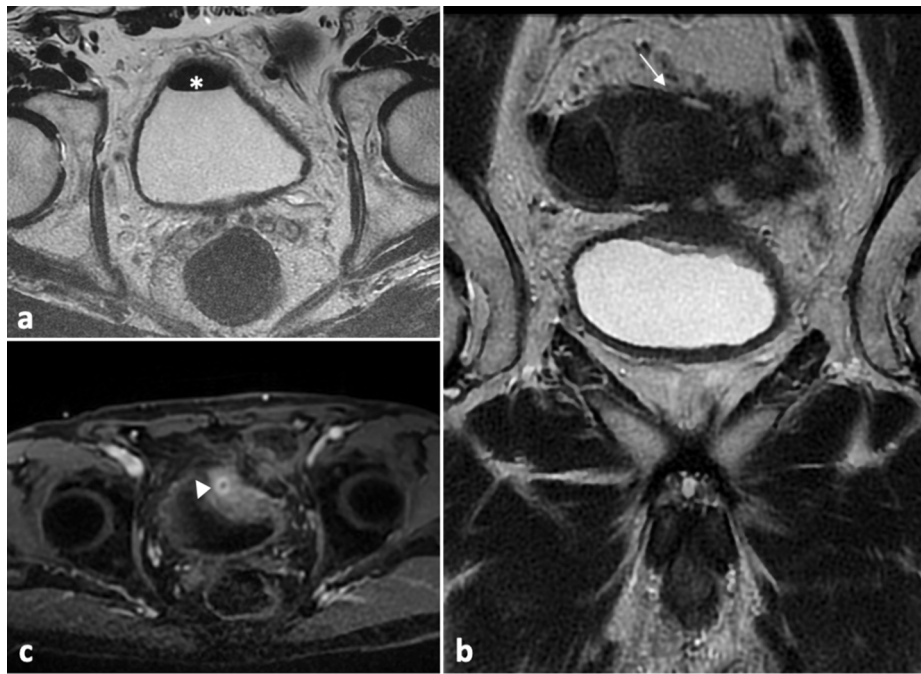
Axial (a) and coronal (b) T2w images show gas within the bladder (asterisk) secondary to diffuse thickening of the sigmoid colon wall (arrow) with an enhancing fistulous connection towards the bladder depicted on axial DCE image (arrowhead in c), in keeping with colo-vesical fistula. T2w T2-weighted, DCE dynamic contrast enhanced.
